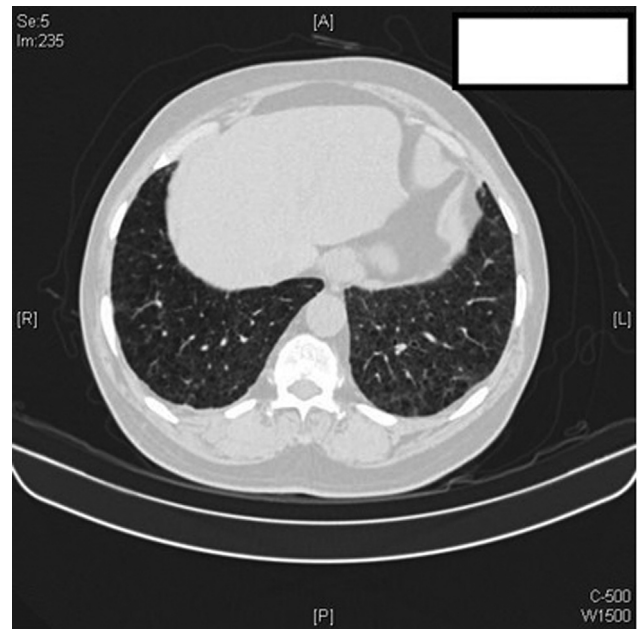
High-resolution chest CT scan: significant clearing of left lower lobe interlobular septal thickening and ground-glass opacities with minimal residual right pleural thickening. Centrilobular emphysema is well appreciated here.
